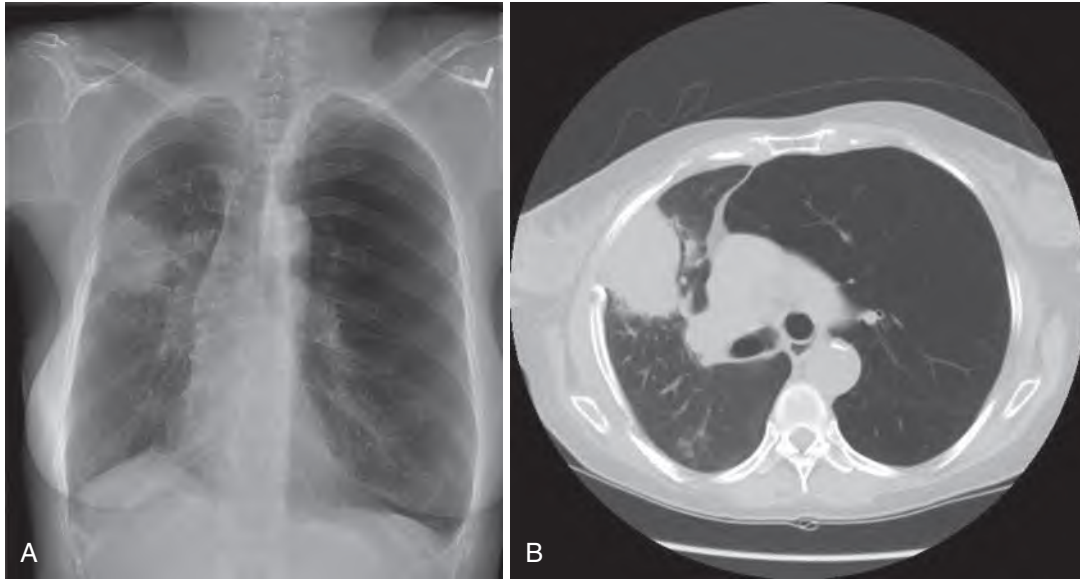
(A) This 64-year-old black female who underwent single-lung transplantation for chronic obstructive pulmonary disease presented with fever and cough for 10 days. The chest radiograph revealed a dense and well-circumscribed nodular infiltrate in the right midlung zone. Blood and bronchoalveolar lavage cultures were positive for *Rhodococcus equi*. (B) A computed tomography scan of the same patient reveals a pleural-based, large, masslike lesion without cavitation in the transplanted lung.
